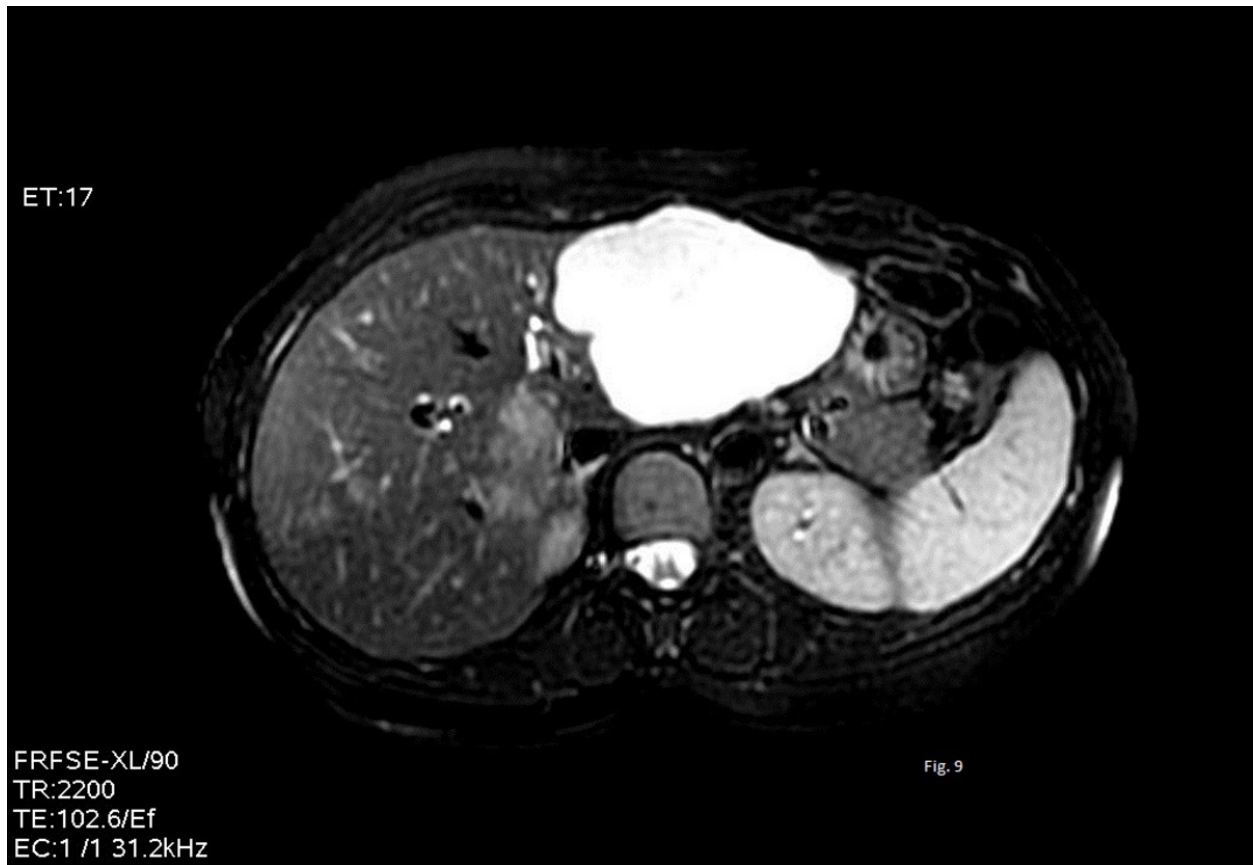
MRI performed two years after diagnosis and OC withdrawal: fat-suppressed T2-weighted image
